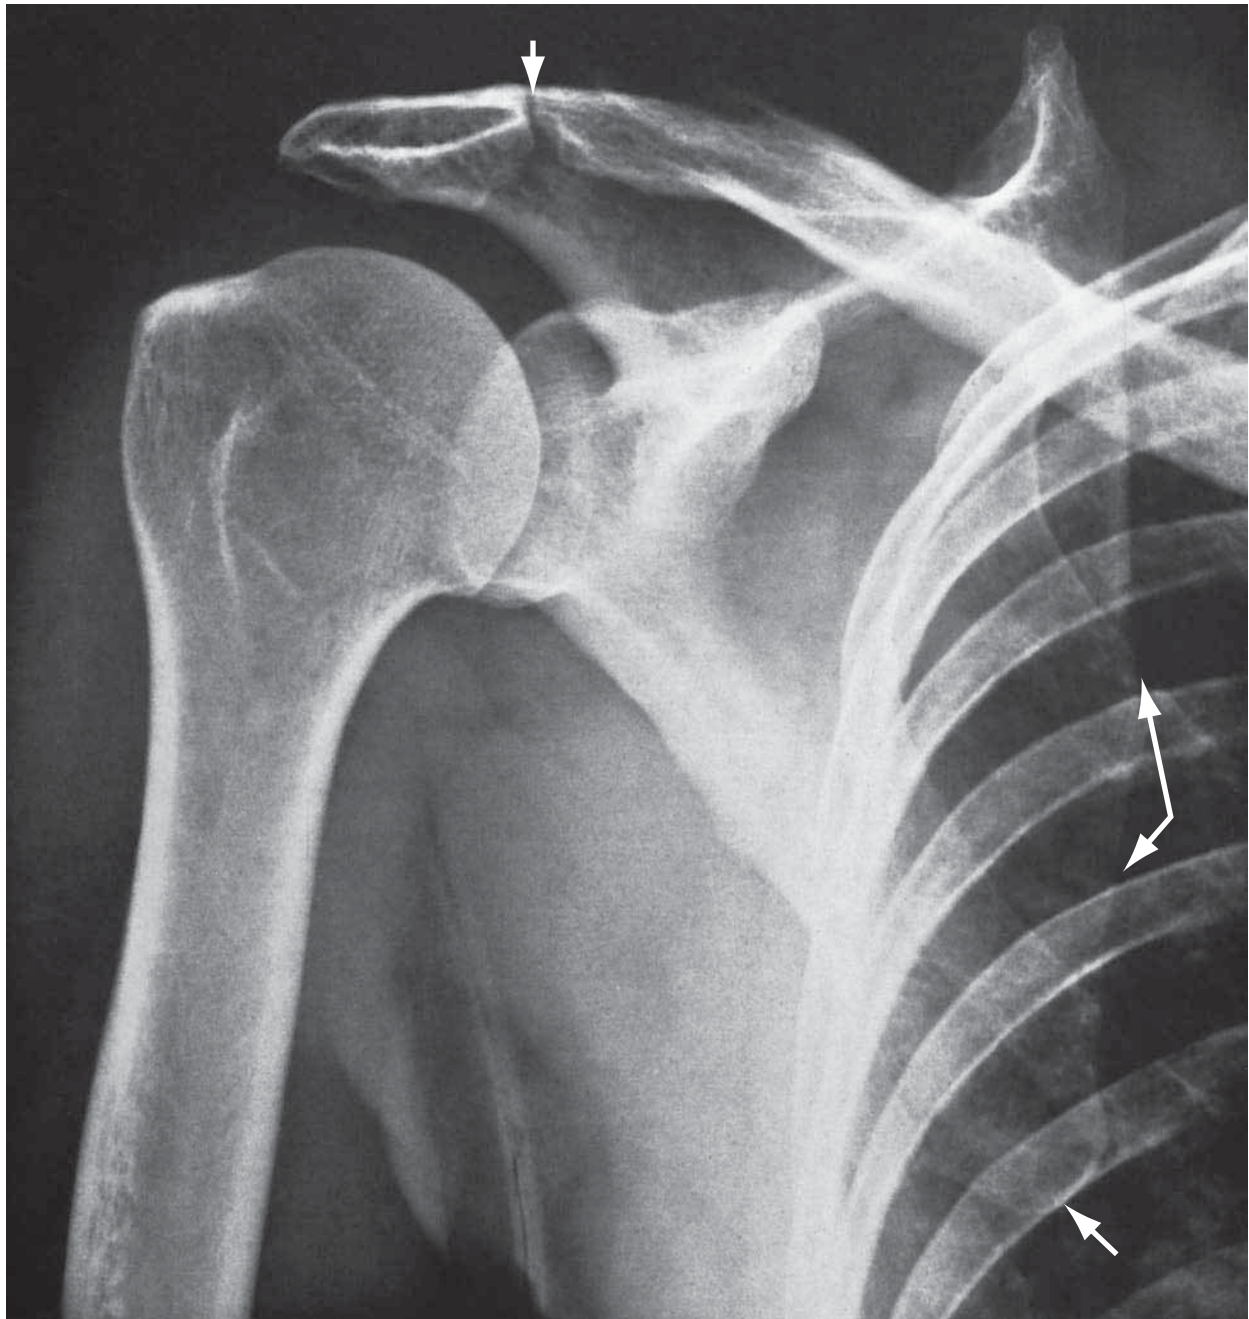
Radiograph of the Right Shoulder Region
